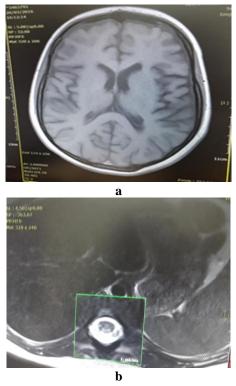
(a and b) Brain and spinal cord magnetic resonance imaging
